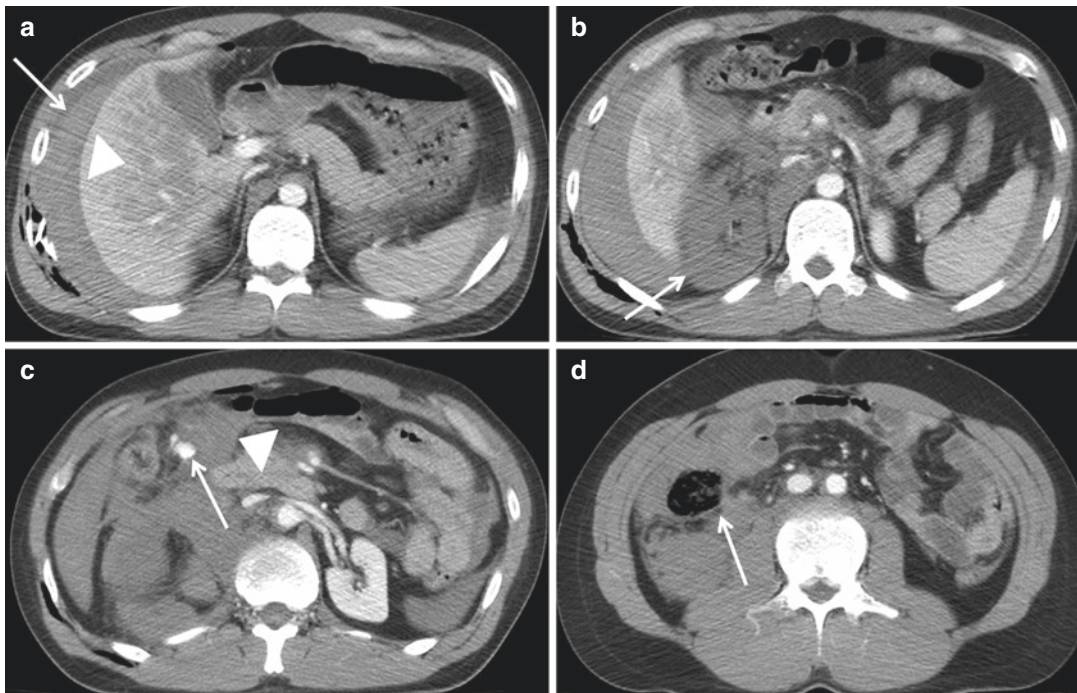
High-energy blunt abdominal trauma. Axial CT images show rib fractures (*curved arrow in a*), hemothorax (*arrow in a*) and hepatic contusion (*arrowhead in a*), devascularization of the right kidney (*arrow in*
